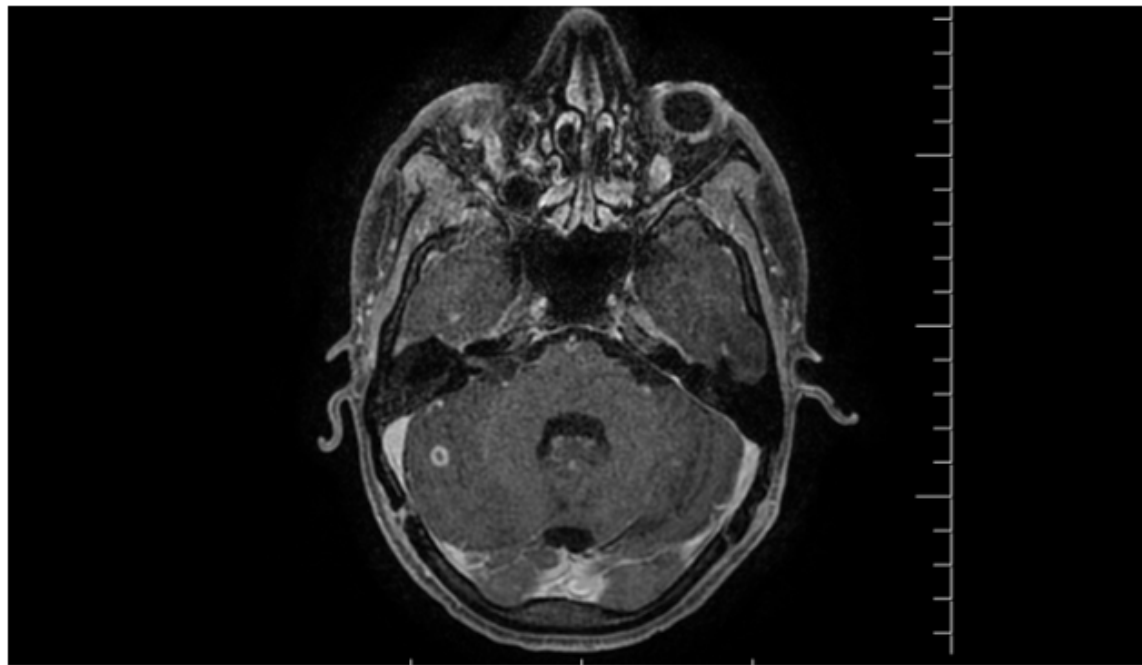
Brain MRI suspicious RT cerebellar tuberculoma.
